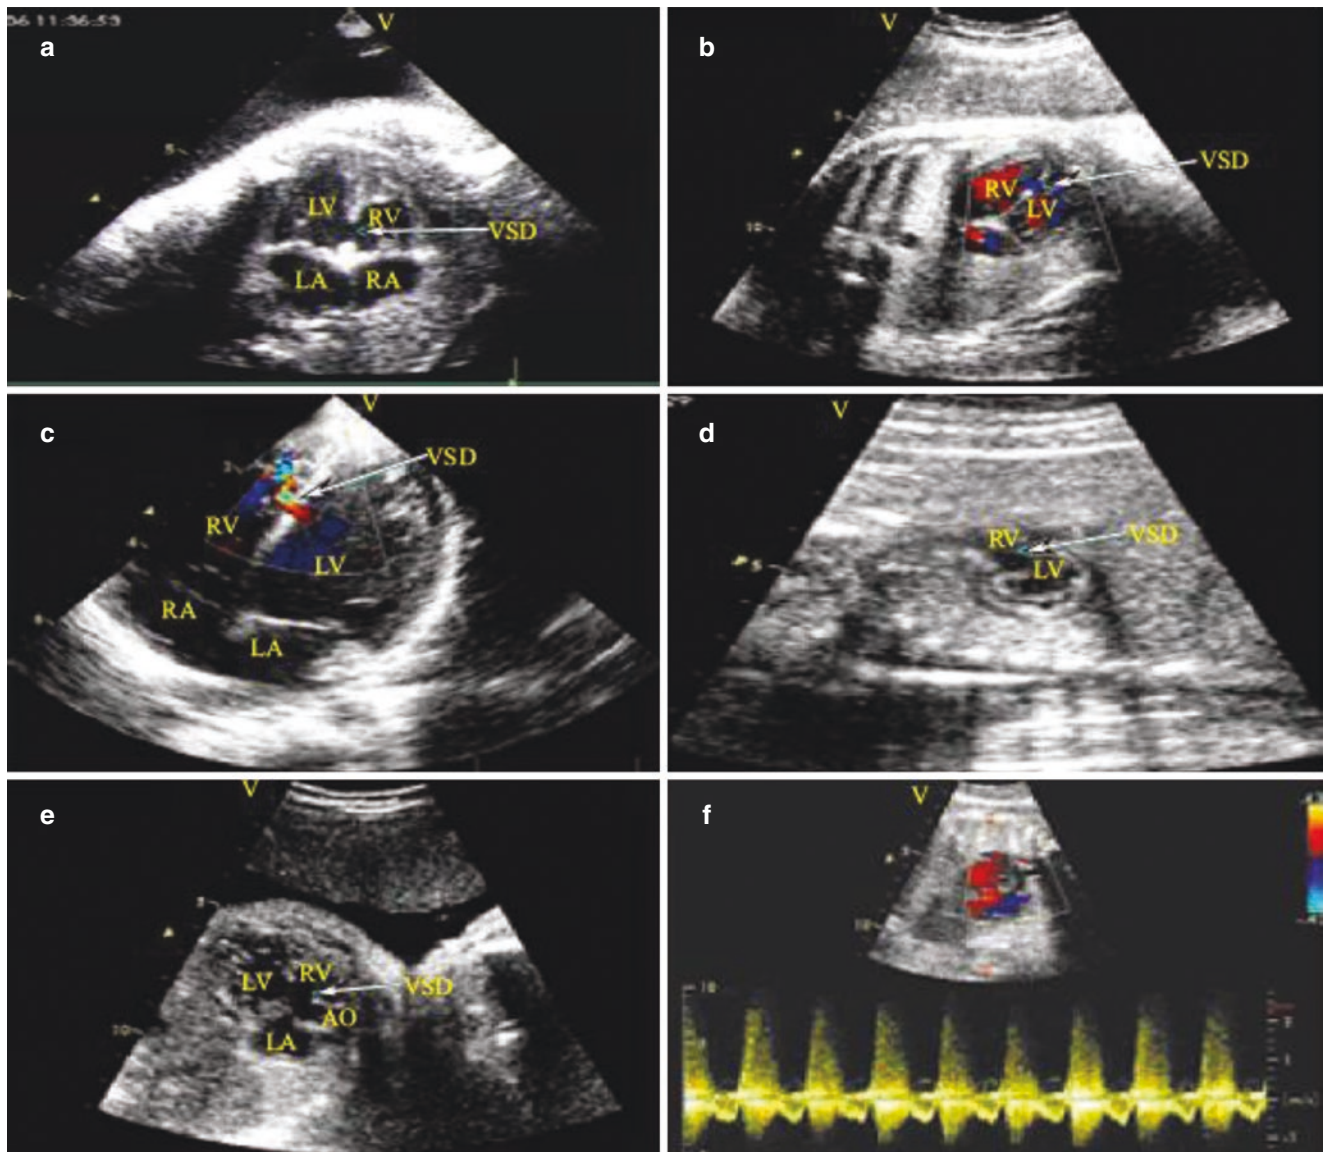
Ventricular septal defect. (a) 2-D four-chamber view demonstrates the defect of the ventricular septal muscle; (b) Color Doppler imaging of a right-to-left shunt in four-chamber view, at the part of muscular part at ventricular level; (c) Left-to-right shunt in four-chamber view of the same child after birth, at the part of muscular part at ventricular level; (d) 2-D ultrasound shows the defect of muscular
